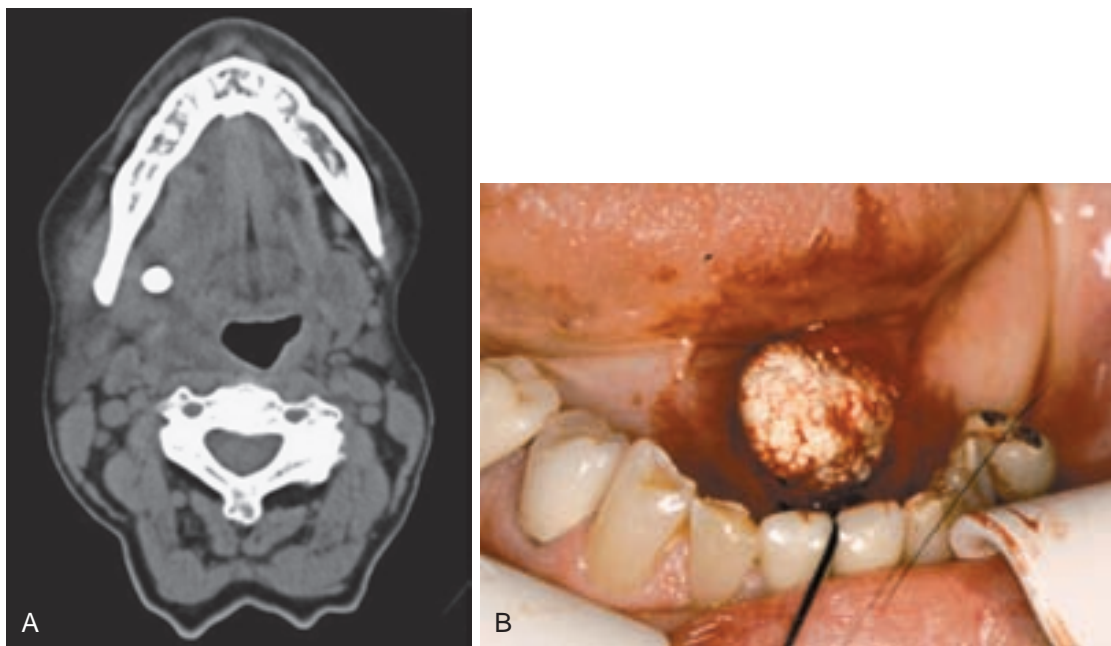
A, Axial CT scan of sialolith in submandibular duct. B, Sialolith of submandibular duct. (Courtesy of Dr. Bonnie Padwa, Children's Hospital, Boston, Mass.)
